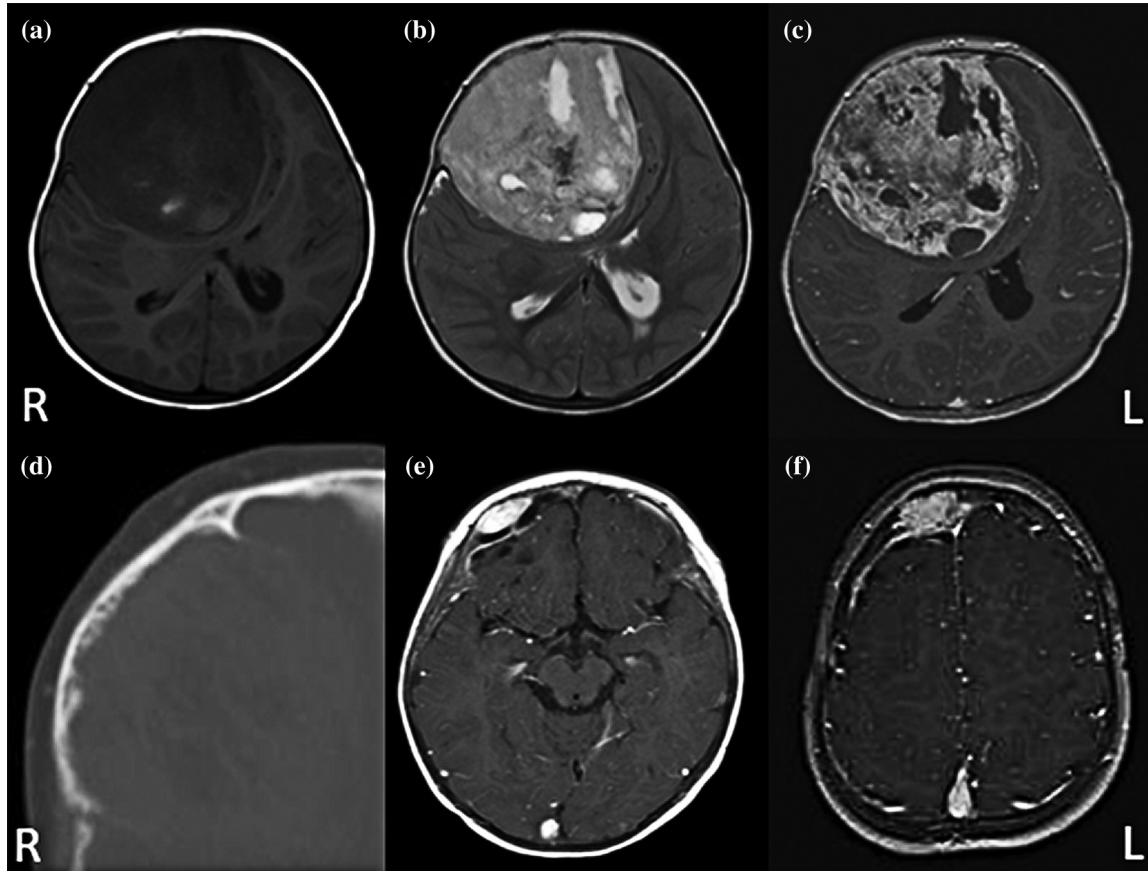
Initial preoperative MR images of the tumor T1WI (a), T2WI (b), and Gd-enhanced T1WI (c). Initial preoperative bone level CT images of the tumor (d). Gd-enhanced MRI images of the tumor at first (e) and second recurrences (f). CT: computed tomography, Gd: gadolinium, MRI: magnetic resonance imaging, T1WI: T1-weighted image, T2WI: T2-weighted image.
